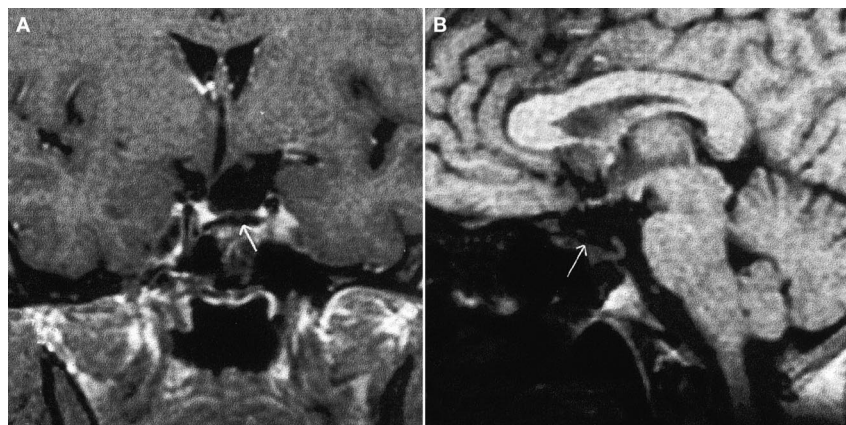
Postoperative T1 coronal magnetic resonance images showing a postoperative empty sella after complete removal of the lesion in coronal (A) and sagittal (B) projection with an absent intensity signal. Arrows indicate the layer of dural substitute.
